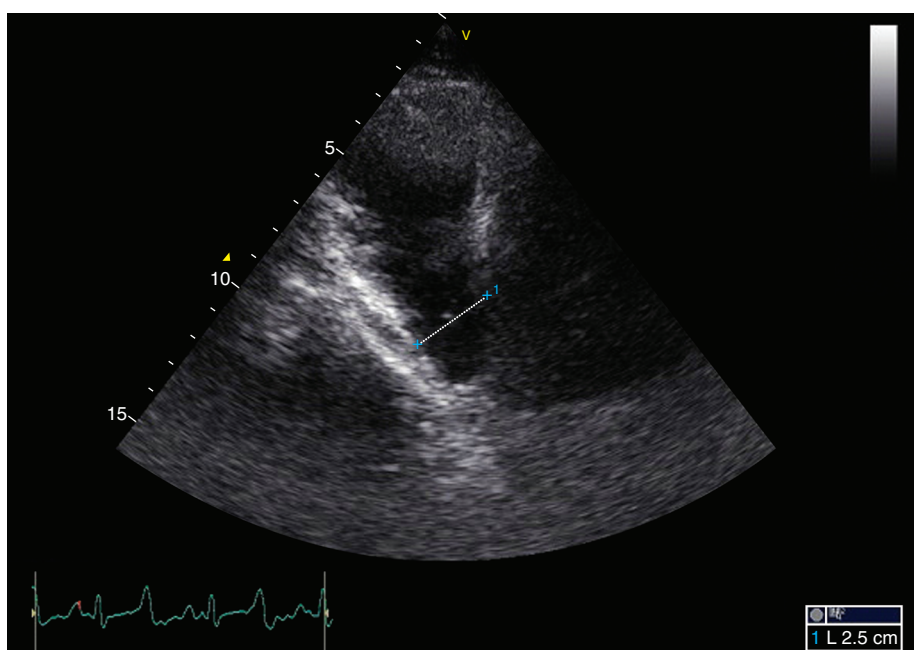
Right parasternal right ventricular inflow-outflow view used to measure pulmonary artery diameter at the pulmonary artery sinus (1)
